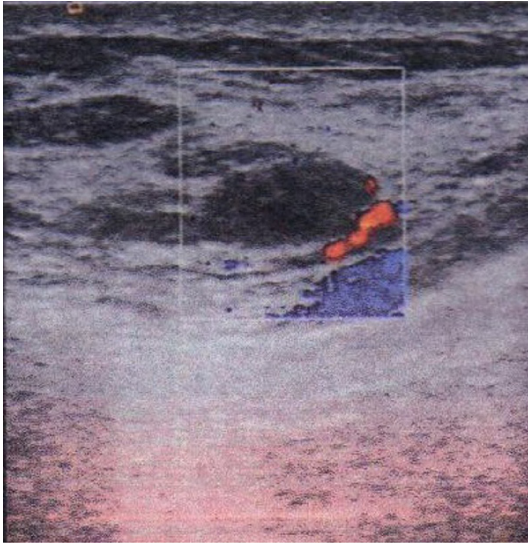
The appearance of hyperplasia of mammary gland in ultrasonography. In the figure, the black space in the box is a hyperplasia of the mammary gland.
